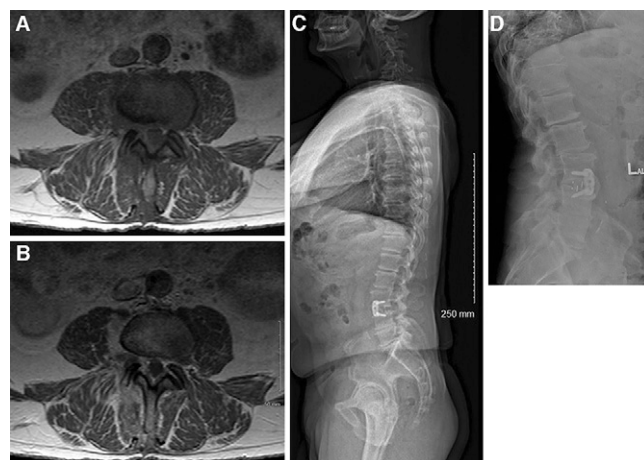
MRI demonstrating clinical course of patient in case 1, a 66-year-old male with epidural fibrosis undergoing lateral lumbar interbody fusion. Axial T1 (A) and T1-weighted (B) images demonstrate presence of epidural fibrosis around the lateral recesses and tracking along the exiting nerve root on the right. C: Lateral standing radiograph shows placement of interbody cage at L3–4. D: Lateral standing radiograph at 1-year follow-up demonstrating stable construct, stable spinal alignment, no hardware failure, and evidence of arthrodesis.
